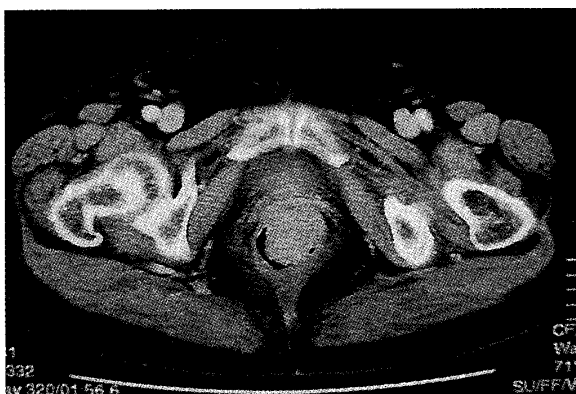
Contrasted-enhanced CT scan showed a high density mass on the anterior rectal wall.
